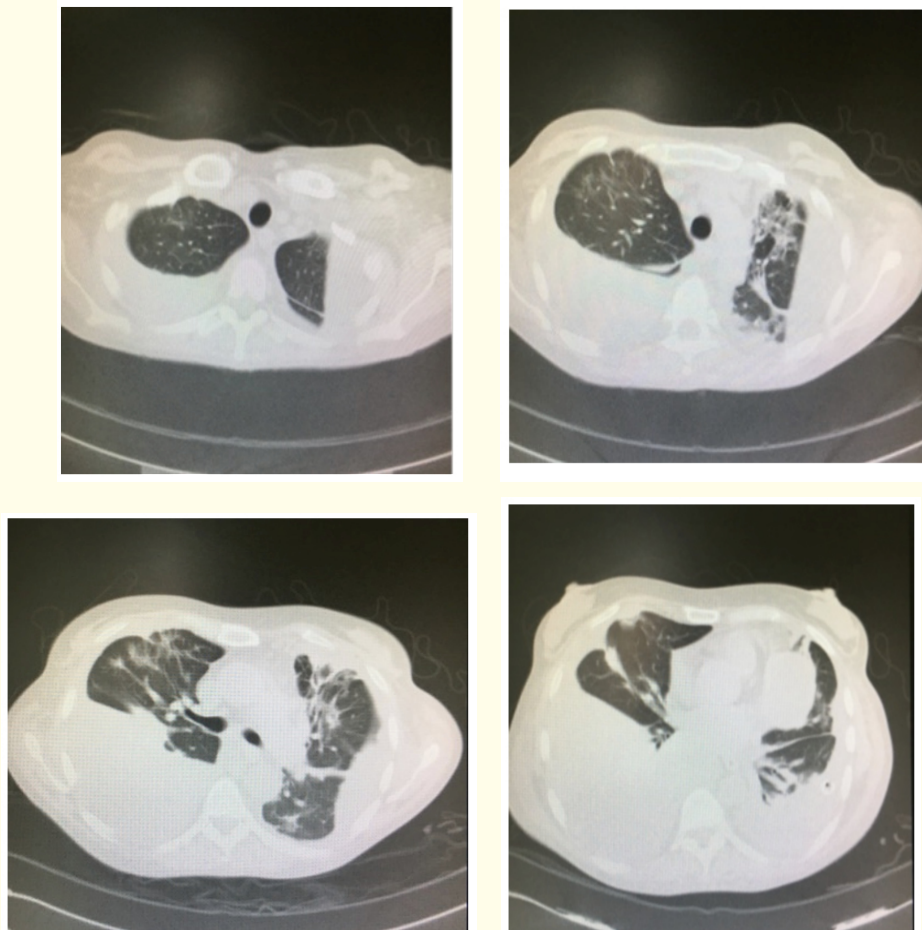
Chest CT on admission.
